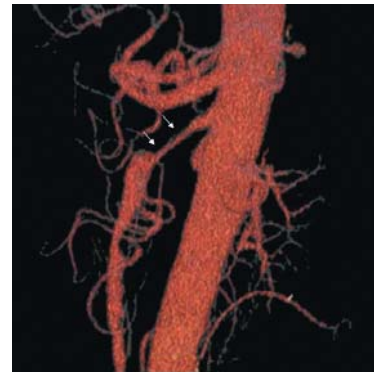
Three-dimensional reconstruction of CT images
